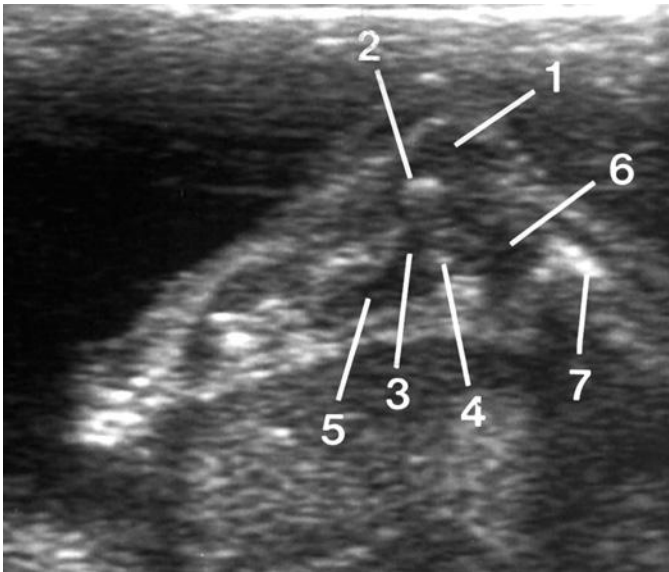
Midsagittal sonogram of the fetal foot in late second trimester. 1, cartilaginous calcaneus; 2, primary ossification center of calcaneus; 3, cartilaginous talus; 4, primary ossification center of talus; 5, tarsal navicular in cartilage; 6, distal tibial epiphysis; 7, distal tibial diaphysis.
